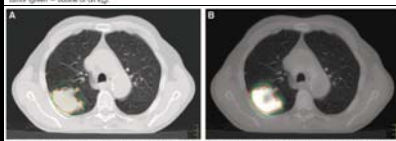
Planning CT scan (A) and corresponding fusion image (B) of patient 8 show inadequacy of GTV<sub>ref</sub> (green) in PET-CT fusion image.
